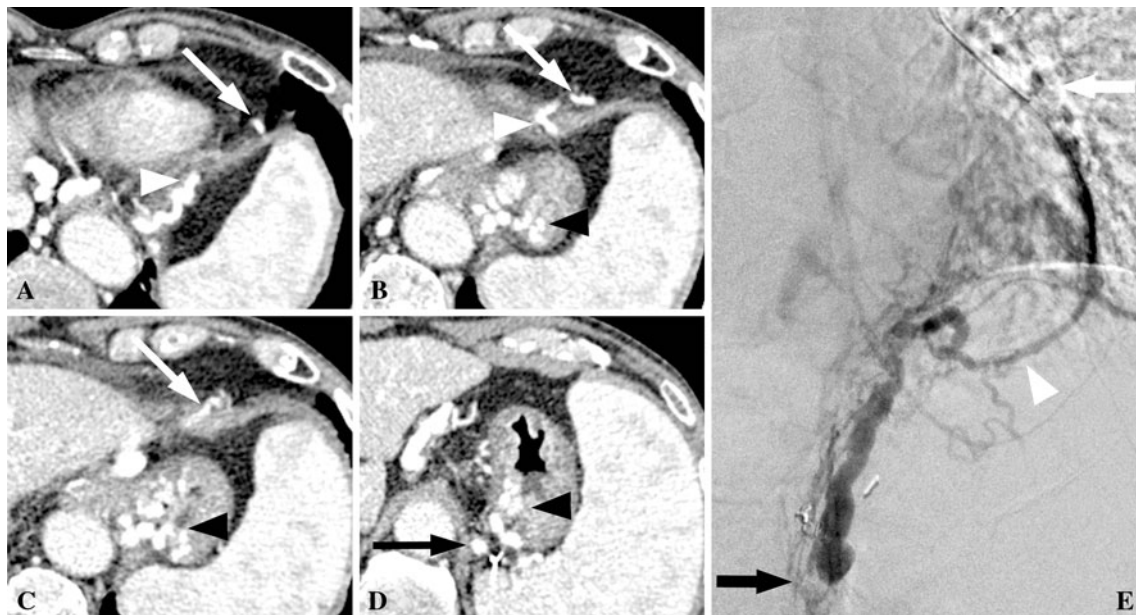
Case 1. A–D Contrast medium-enhanced CT detected that two main draining veins were the pericardiophrenic vein (white arrow) and GR shunt (black arrow). The pericardiophrenic vein connected with inferior phrenic vein (white arrowhead) and gastric varix (black
